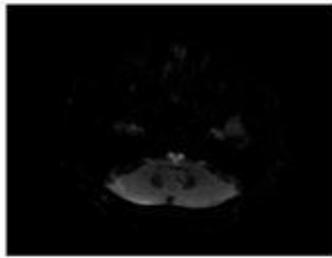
Bilateral medullary infarcts in 71 years old male patient. Diffusion weighted 3 Tesla MRI demonstrating V shaped diffusion restriction at bilateral medial medulla oblongata
